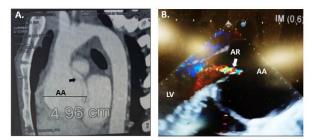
Preoperative Computed Tomography Angiography Scan (A) and Transesophageal Echocardiography (B) showing the aortic root aneurysm and valve regurgitation. The black arrow indicates the intimal tear. (*AA: aortic aneurysm; LV: left ventricle; AR: aortic regurgitation*).
